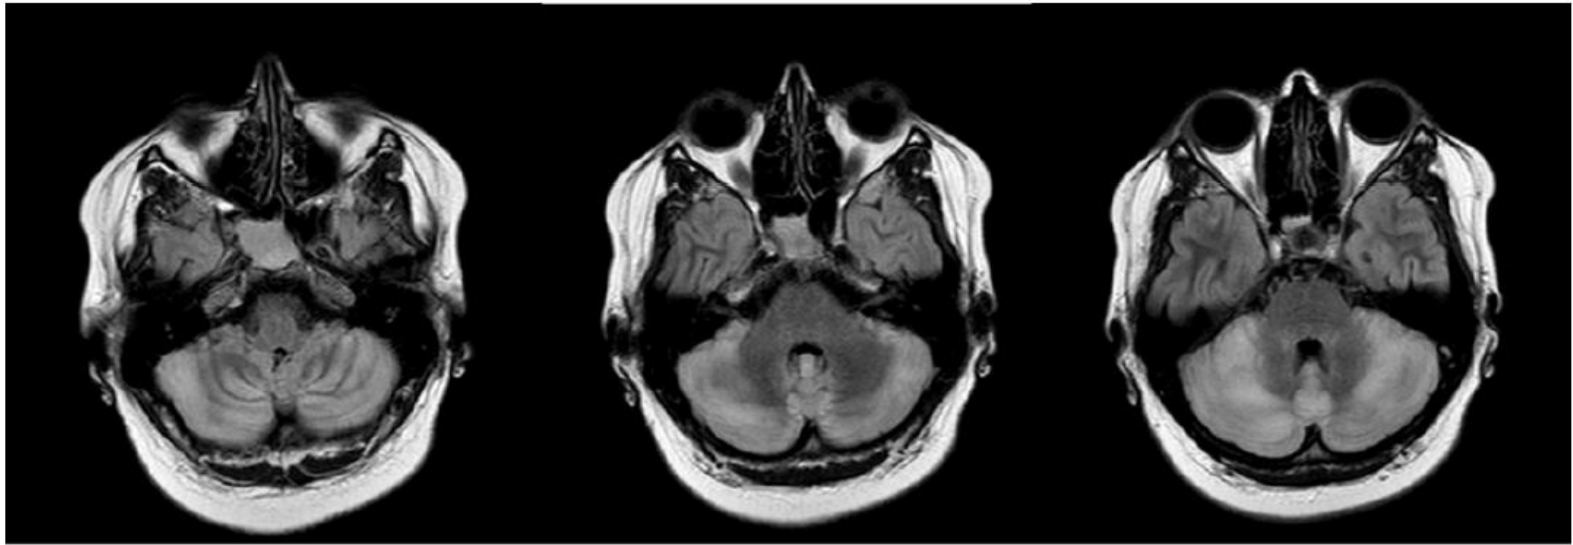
Herpes virus. Hyperintense FLAIR lesions on cerebellum, involving white and gray matter, without restriction diffusion and without enhancement post administration of contrast medium.
